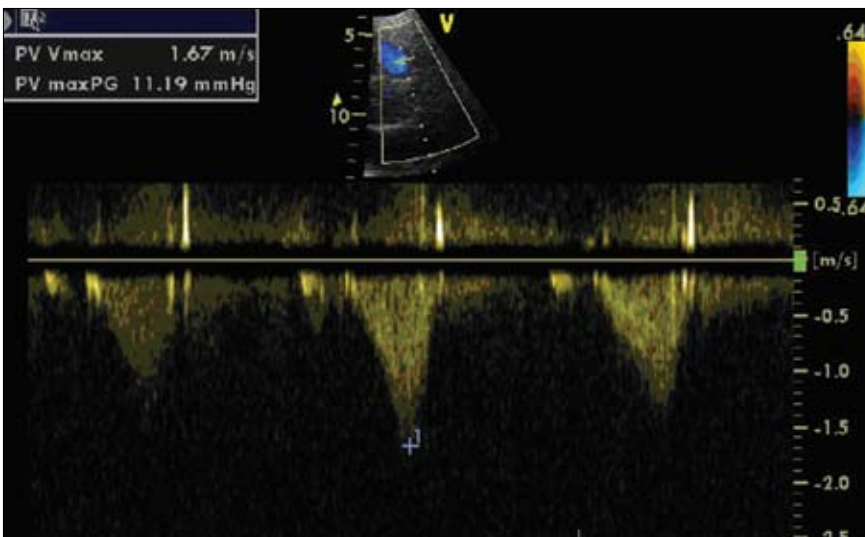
Continuous-wave Doppler flow through the pulmonic valve at 2-month postvalvuloplasty follow-up showing a significant reduction in gradient.
